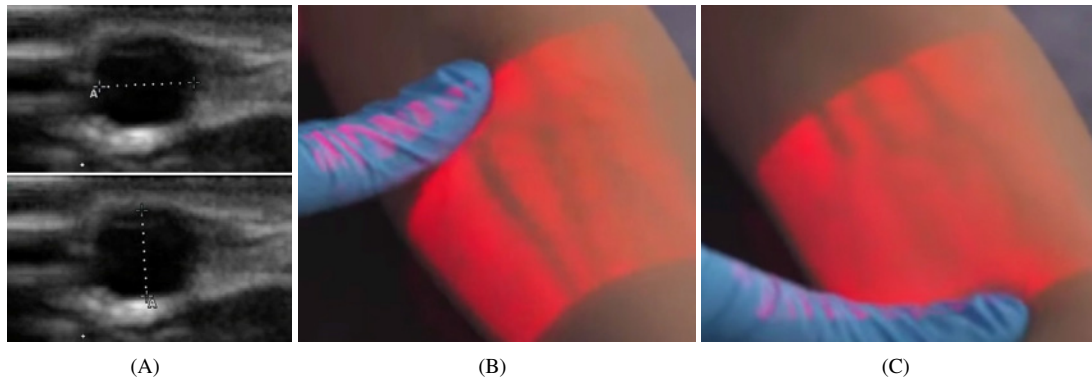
NIR Light Shows Venous Blood But Not Vein Walls. A: 2D-ultrasound images of the author’s hand veins taken with a Sonosite Turbo Ultrasound with L25 linear probe. B-C: Veins disappearing in NIR image (from AccuVein AV400) when blood is squeezed out, meaning that NIR light shows only the venous blood and not the vein walls. Images used with permission of AccuVein Inc.
